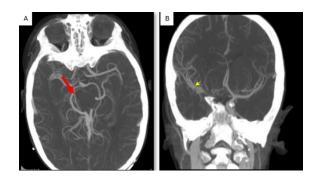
Computed tomography scan with MIP: showing stenosis of the right internal carotid artery (arrow)
